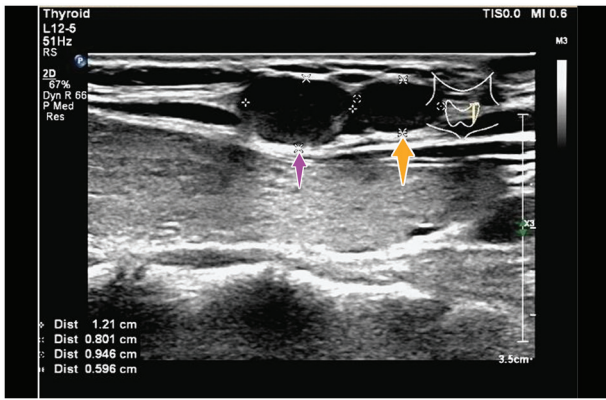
Neck ultrasound image of two hypoechoic subcutaneous nodules (purple arrow, the larger skin metastasis of PTC; orange arrow, the smaller skin metastasis of PTC). PTC, papillary thyroid carcinoma.
